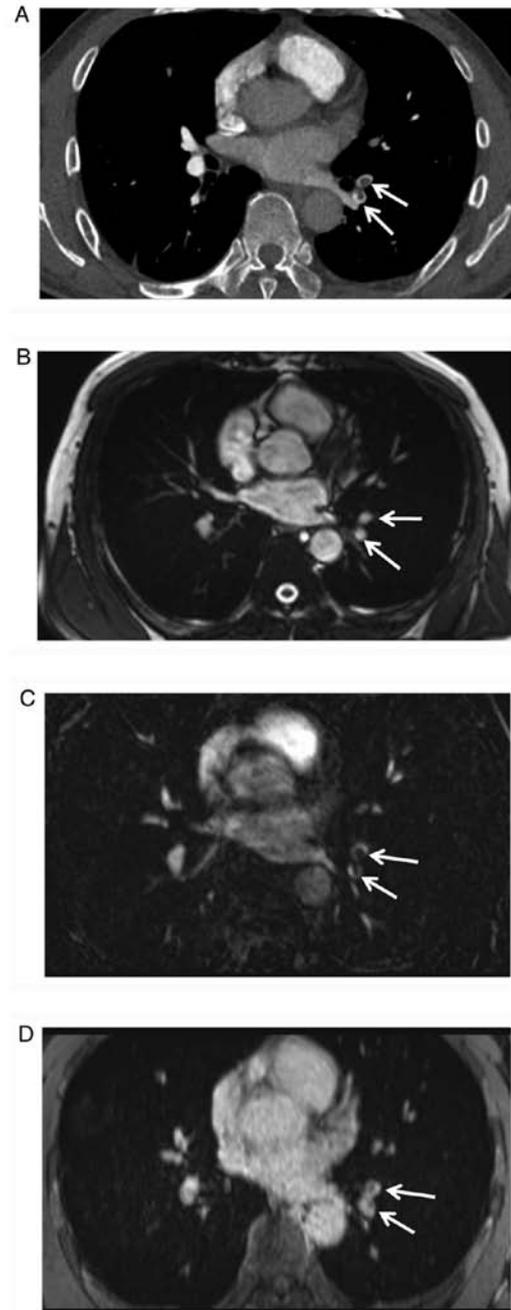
Representative case of a 49-year-old female with segmental pulmonary embolism. (A) CT pulmonary angiography revealed emboli in the lateral and posterior basal segmental pulmonary arteries (arrows). (B) True fast imaging with steady-state precession axial image failed to depict the emboli displayed in A. (C) Contrast-enhanced MR pulmonary angiography and (D) enhanced volume-interpolated body examination successfully displayed the emboli depicted in A clearly in the axial images.
